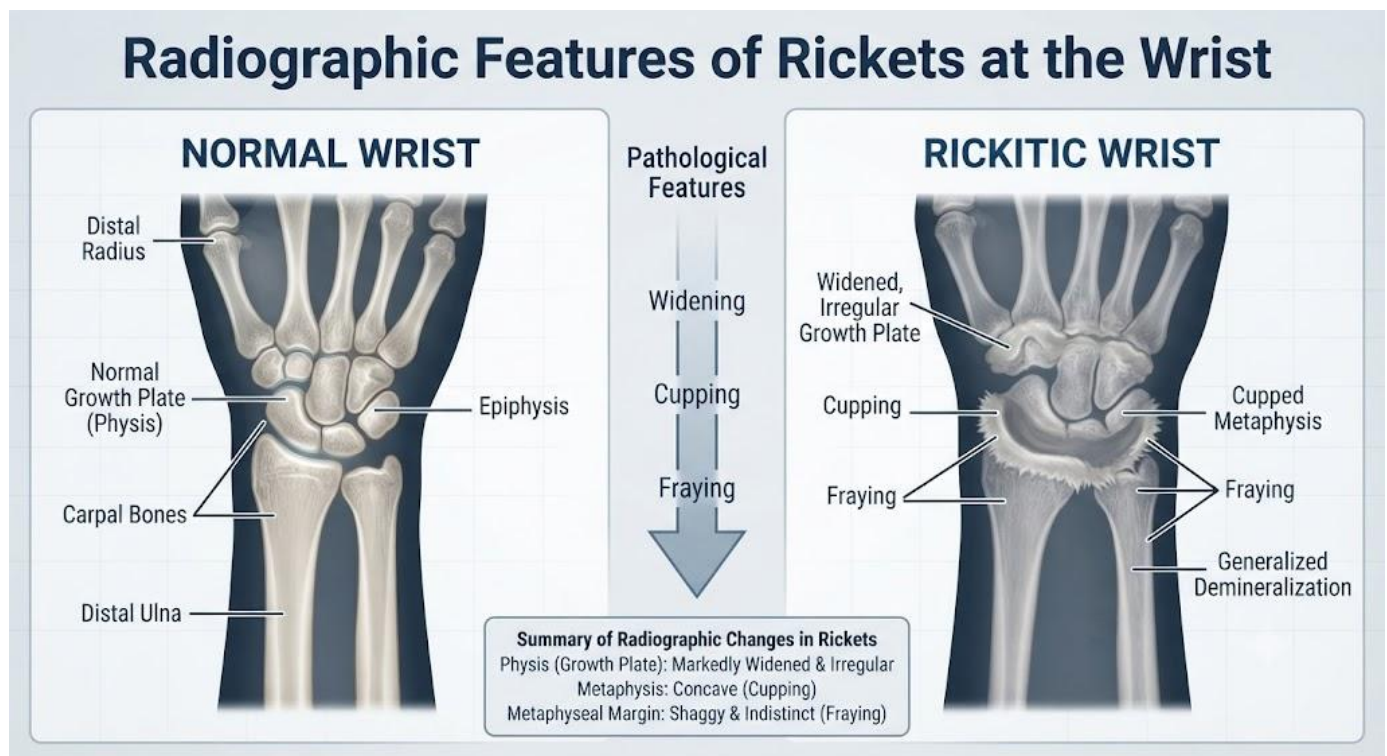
Characteristic radiographic features of rickets at the wrist.
